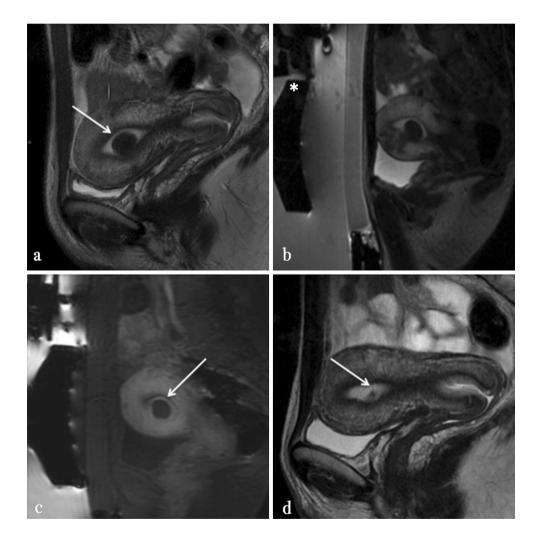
38-year-old woman with uterine myoma treated with MRIguided high-intensity focused ultrasound ablation (MRgFUS); a T2weighted image from screening MRI examination shows a submucosal uterine fibroid (*arrow*) in anterior wall of anteverted uterus; b sagittal T2-weighted MR image acquired during treatment planning shows prone patient on the MRI table top and the HIFU transducer (*); the bladder is not completely empty to optimize the position of the uterus for the treatment; c sagittal T1-weighted gadoliniumenhanced image acquired at the end of the treatment demonstrates the effect of the ablation, as an area of non-perfusing volume corresponding to coagulative necrosis (*arrow*); d posttreatment (24 months) sagittal T2w image shows the quite complete disappearance of the treated fibroid; the endometrial line appears normal (*arrow*) treatment. This is one of the reasons why it is strongly suggested to concentrate the treatment on the dominant fibroid alone [67, 68]. The fibroids are defined "dominant" when associated with symptomatology [Fig. 2]. In the presence of multiple fibroids, it will be more likely that one or more are not responsible for symptomatology.
